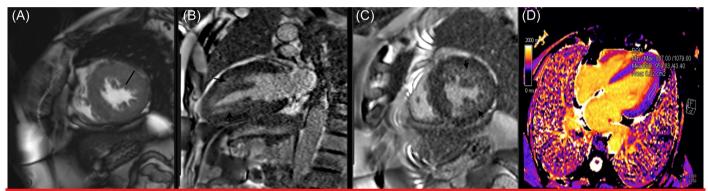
Cardiac Magnetic Resonance Imaging. (A) Short-axis cine SSFP image shows left ventricular hypertrophy (black line indicates increased wall thickness). (B and C) Vertical long axis and midventricular short-axis late gadolinium-enhanced image demonstrates extensive anterior and inferolateral wall segment enhancement (arrows). (D) Horizontal long axis pre-contrast T1 map shows that the ROI is measured at the inferolateral wall has reduced T1 value (959 ms).
